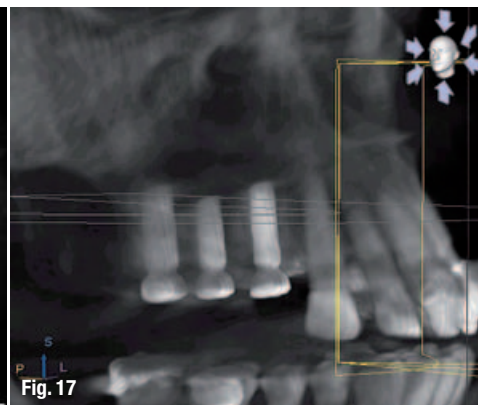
Post-op panoramic CBCT reconstruction showing position of placed implants.
